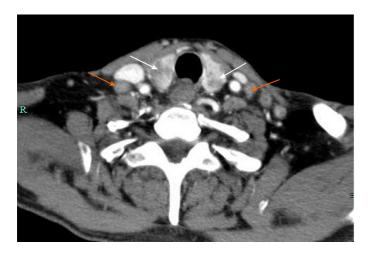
The enhanced contrast neck computed tomography scan shows lesions in the thyroid lobes (white arrows) and enlarged lymph nodes (orange arrows).
